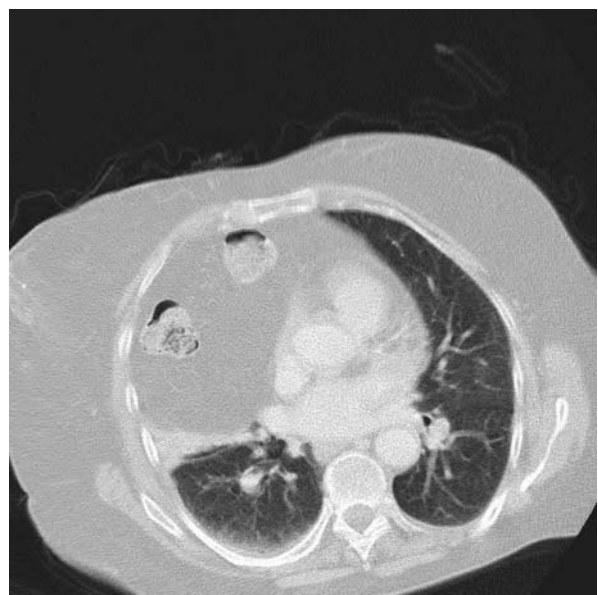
CT scans demonstrating two loops of large bowel in the thoracic cavity.
